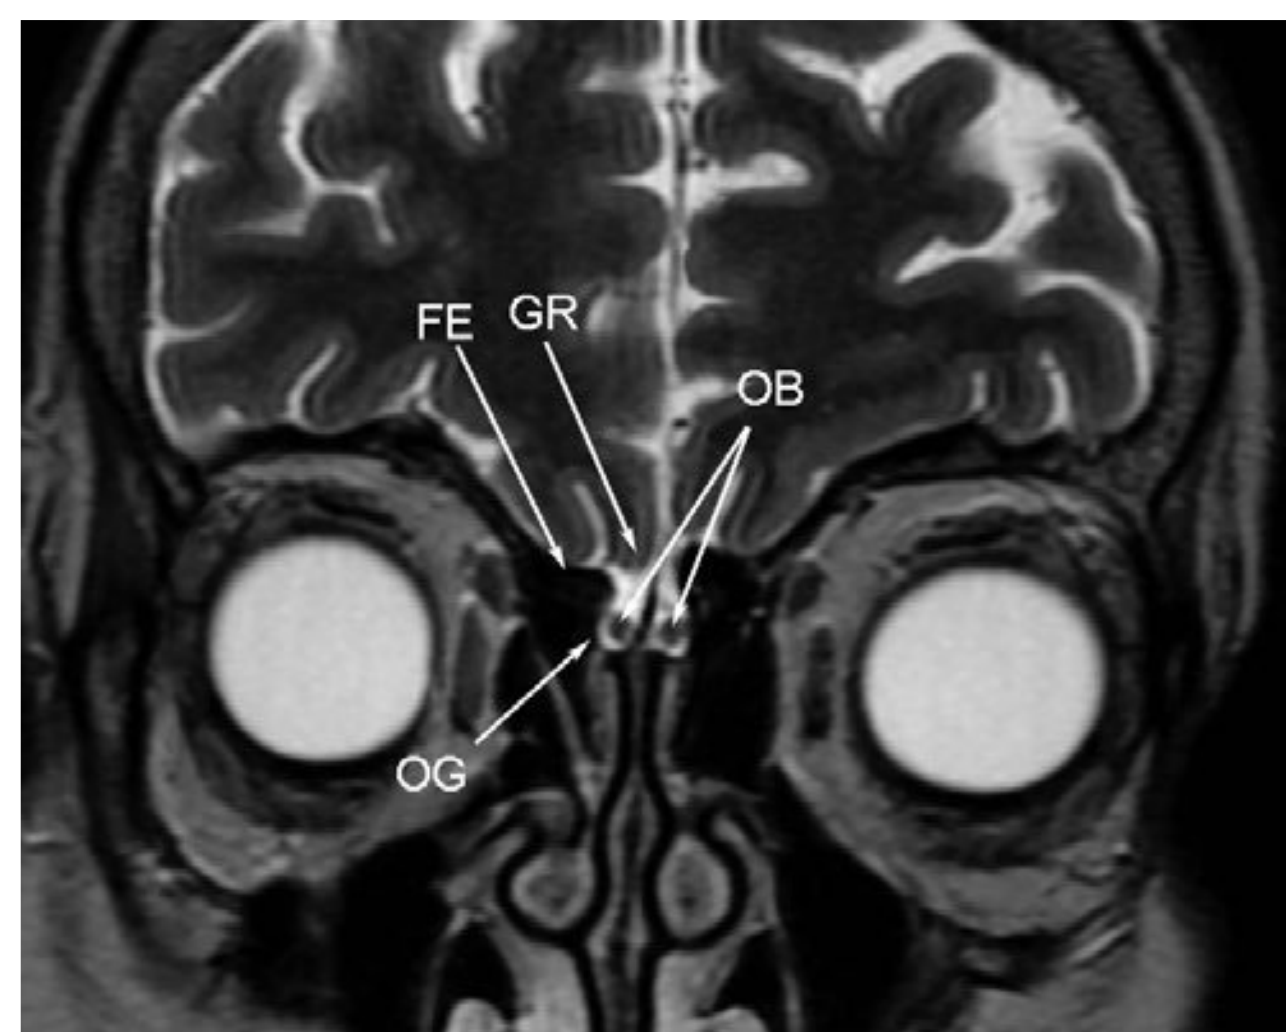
Coronal T2-weighted magnetic resonance imaging through the orbits demonstrates the relationship of the frontal lobes, olfactory bulbs, and olfactory grooves. The olfactory bulbs (OBs) lie inferior to the gyrus rectii (GR) of the frontal lobes. The olfactory grooves (OGs) vary in depth in relationship to the ethmoid roof. The lateral aspect of the ethmoid roof is the fovea ethmoidalis (FE).
